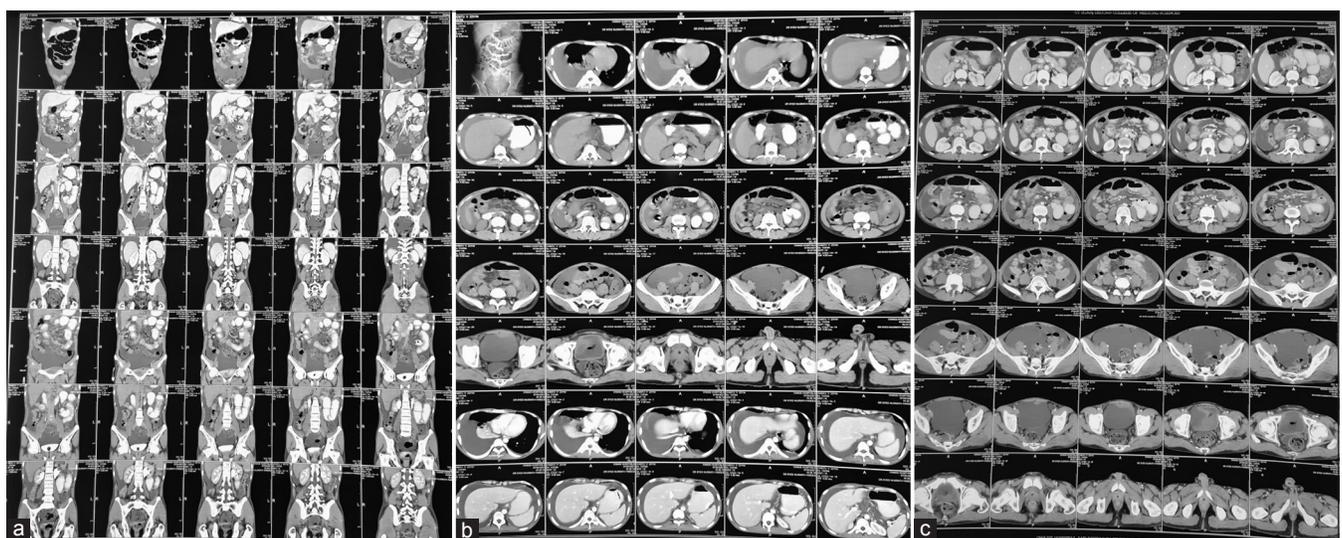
(a) Contrast-enhanced computed tomography abdomen, b and c films show moderate right, left, and non-enhancing well-defined hypodense area (12 × 8 mm) in the neck of the pancreas?
